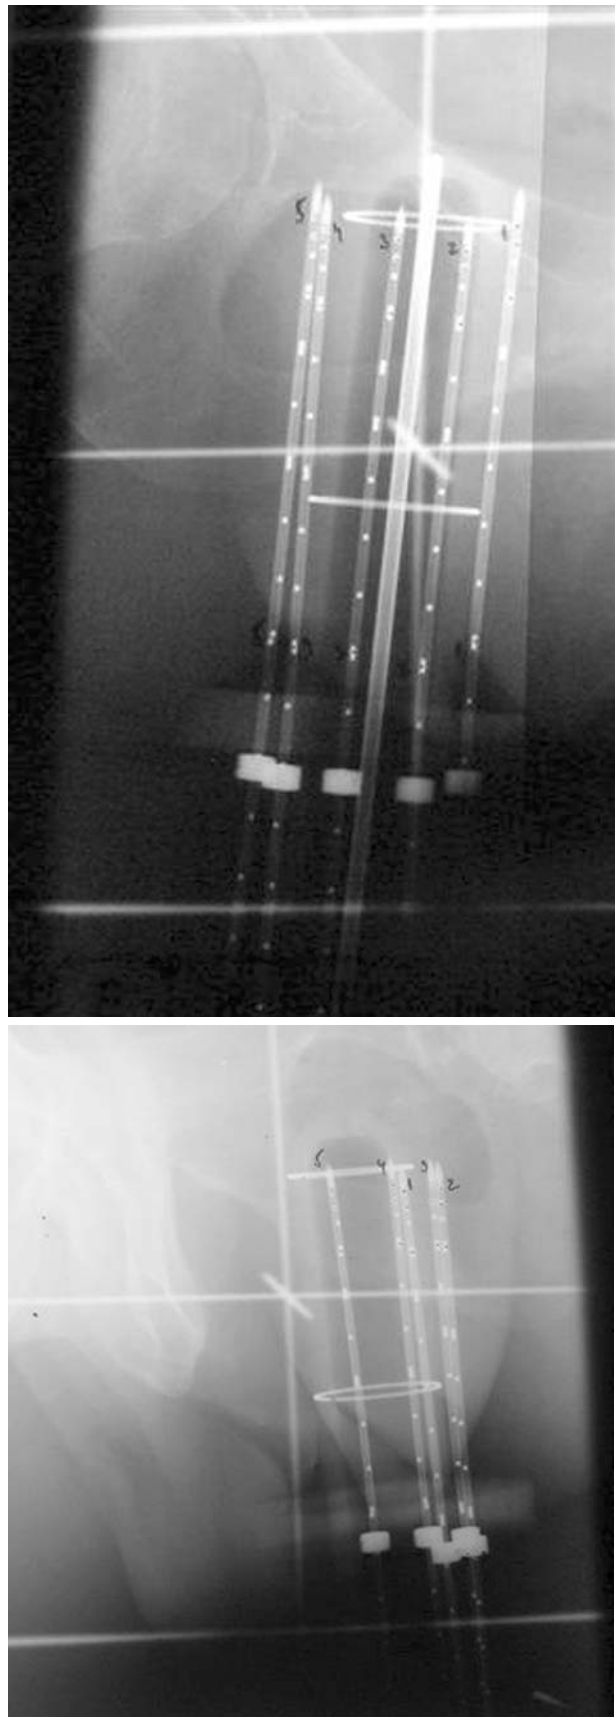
Two orthogonal radiographs for needles reconstruction and dosimetry
